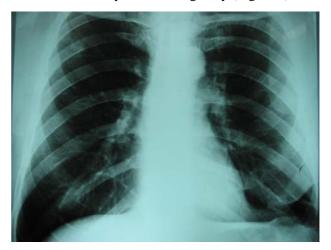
Chest x-ray obtained ten months after the treatment.
